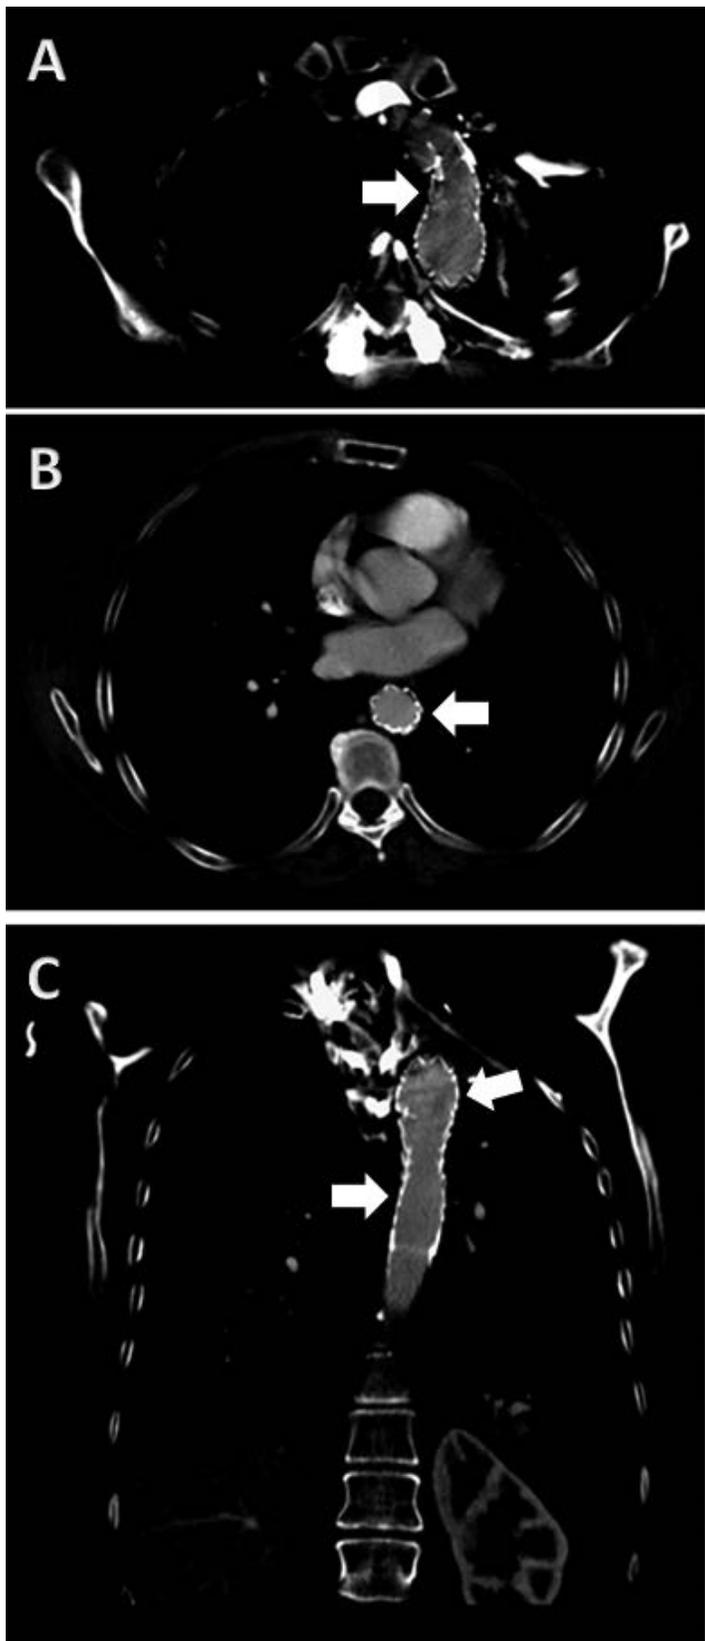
Postoperative magnetic resonance imaging showing extent of thoracic endograft (white arrows) from (A) distal aortic arch to (B, C) descending thoracic aorta.
